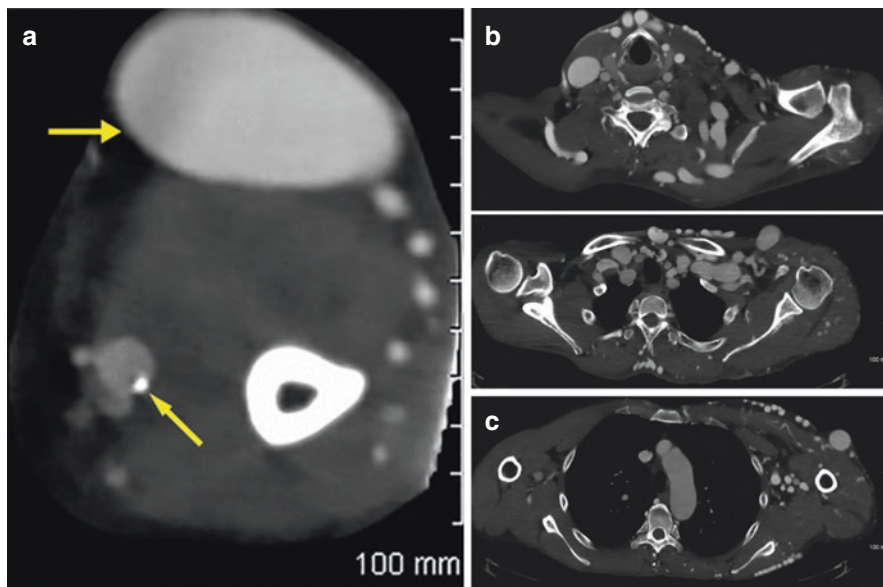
(a) CTA showing a brachial artery catheter (thin yellow arrow) placed for CTA evaluation of a failing left arm radio-cephalic dialysis access circuit. Note the large, aneurysmal outflow vein (thick yellow arrow). (b–d). Extensive collaterals in the upper arm, axilla, chest wall, mediastinum due to bilateral subclavian vein chronic occlusion
